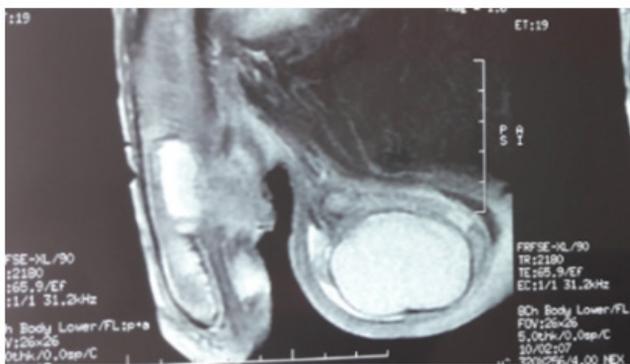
MRI shows the presence of bilateral inguinal ganglions infracentimetric and the absence of extension in the organs of the neighborhood
